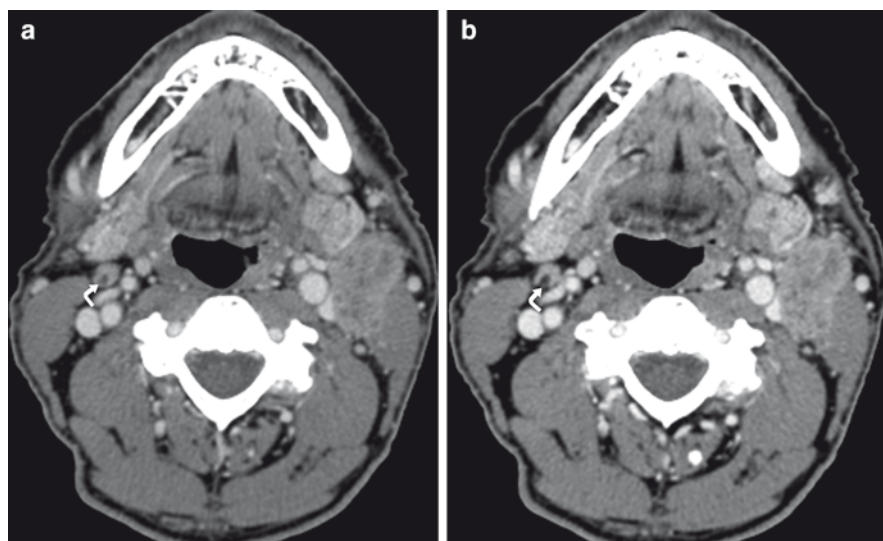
Metastatic carcinoma to the left neck. (a) Axial CT image, in addition to obvious left-sided nodal disease, suggests the possibility of necrosis within a contralateral node (*curved arrow*). (b) The image at a slightly lower level shows that, rather than necrosis, this is a normal fatty hilum (hypodense area, *curved arrow*). The image more superiorly represents partial volume averaging and thus the illusion of necrosis that does not exist
